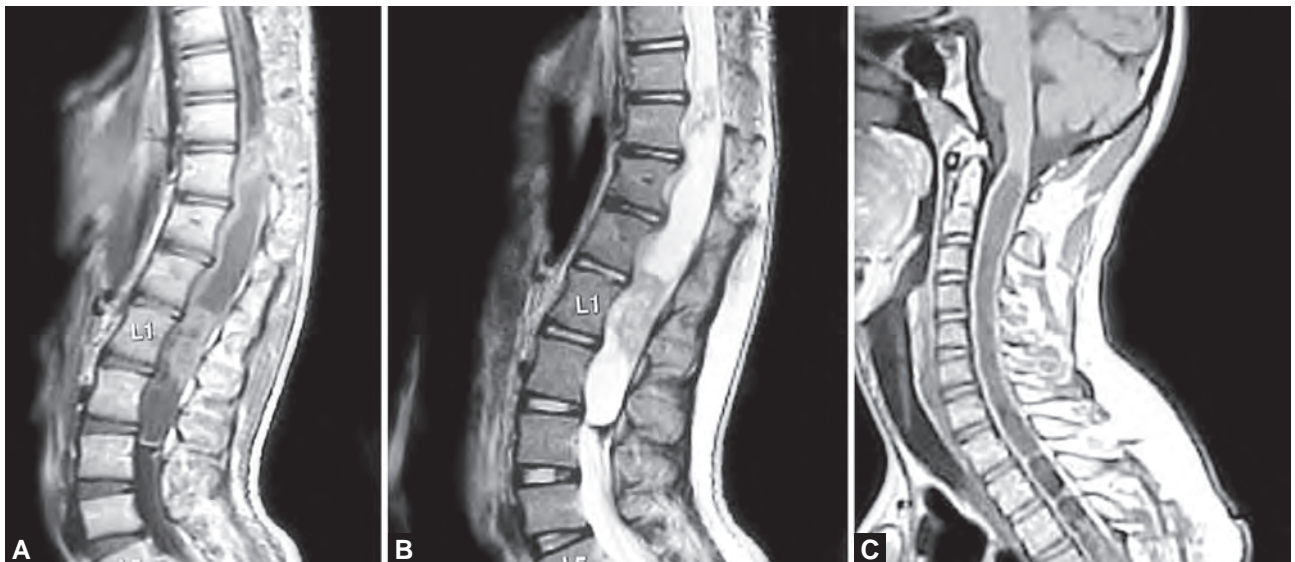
(A) MRI sagittal T1. (B) T2 showing cervicodorsal syrinx in a patient with CV junction anomaly
